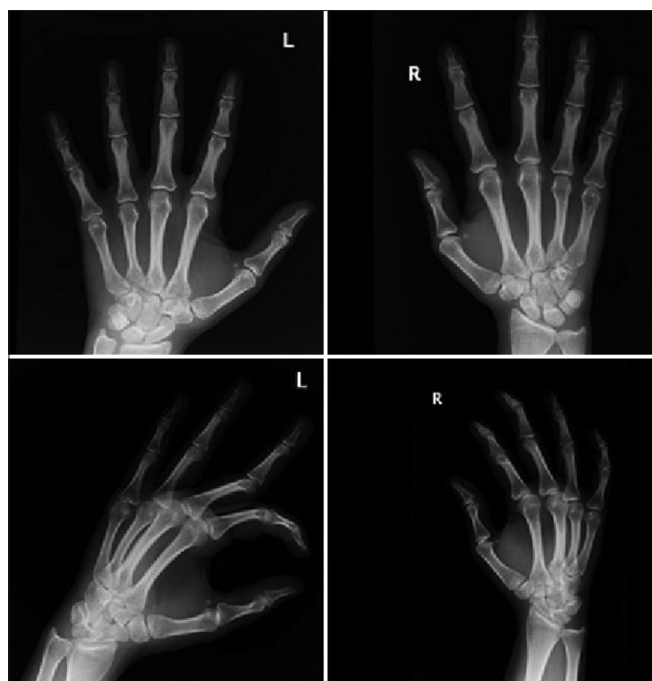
Radiographs of the left hand at 18th month
